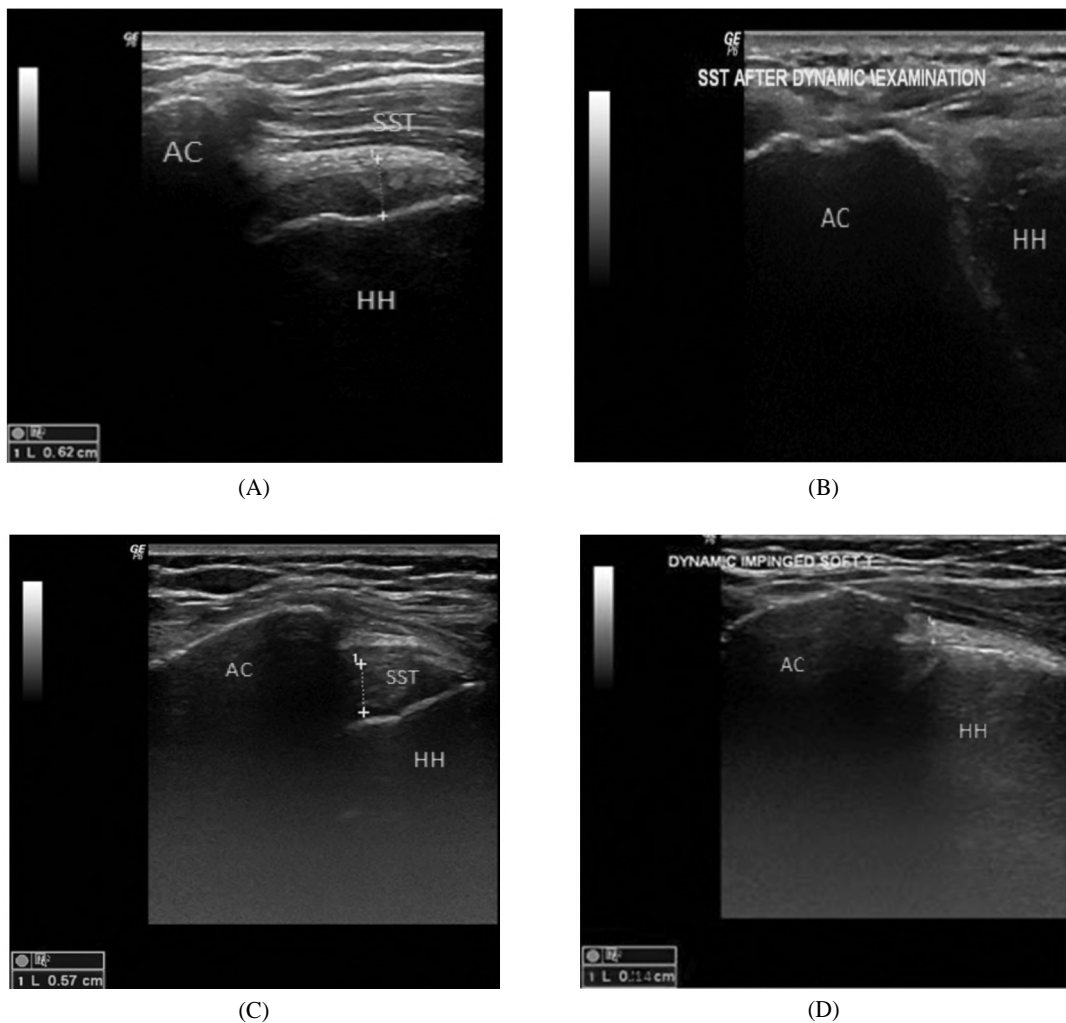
Static (A) Ultrasonography coronal view showed: No evidence of anatomic impingement as the humeral head (HH) passed easily and freely underneath the acromion (AC) & dynamic (B) with pain during shoulder motion (grade 1 impingement) (SST: Supraspinatus tendon). Follow-up by static (C) and dynamic (D) Ultrasonography coronal view showed: Relative narrowing (0.57cm) of the subacromial tunnel that became accentuated in stress position with soft tissue impingement (grade 2) (HH: Humeral head, SST: Supraspinatus, AC: Acromion).
